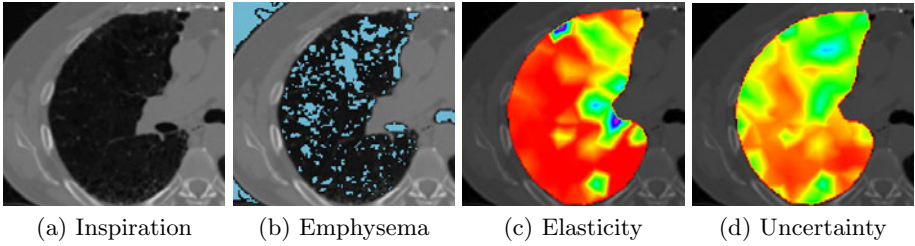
Emphysematous tissue. The elasticity and uncertainty maps are color coded using the rainbow colormap in Fig. 3(c) and the window levels (4000/2000) and (300/150) for figures (c) and (d) respectively. (a) Axial slice of the inspiration CT dataset. (b) Thresholded image at -950Hu to identify emphysematous tissue and overlaid on the axial slice in (a). (c) Estimated elasticity map. Notice how the elasticity in the lower part of the image is relatively homogeneous, while in the upper area where the emphysema is most predominant it appears stiffer. The reason may be that this emphysematous region is not ventilated and the air filled emphysematous regions do not collapse during expiration. (d) Uncertainty map. We can see that because of the emphysematous regions and consequently the lack of image information, the uncertainty is larger in the area of emphysema compared to non-emphysematous regions.
